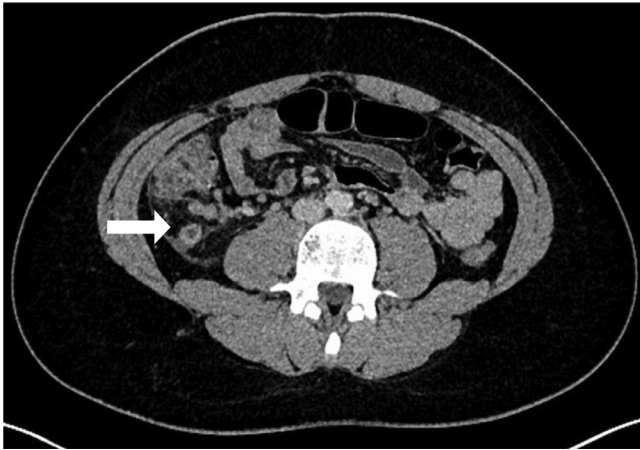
Patient 3–13-year-old male axial contrast-enhanced CT shows a dilated, hyperenhancing appendix (arrow) with a small amount of peri-appendiceal fluid, compatible with acute appendicitis.
